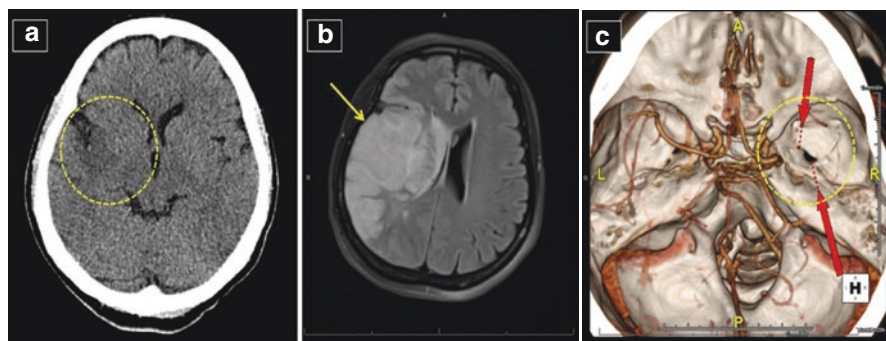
Ischemic stroke on radiologic imaging. (a) Dense MCA sign found on noncontrast head CT scan. (b) Brain MRI demonstrating right MCA stroke. (c) Cerebral angiographic reconstruction demonstrating 100% occlusion of the right MCA. *MCA* Middle cerebral artery, *CT* Computed tomography, *MRI* Magnetic resonance imaging
